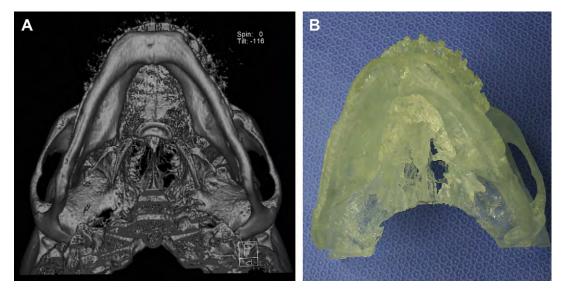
(A, B) Three-dimensional CT scan and stereolithographic model showing very thin ramus.
